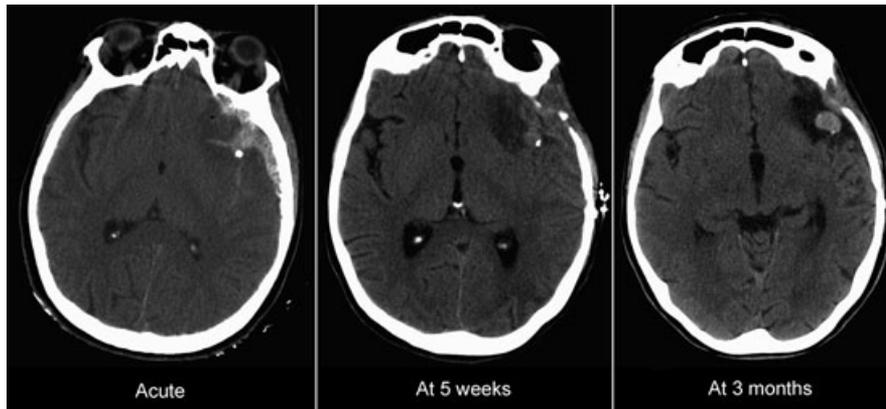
Initial head CT (acute) shows hemorrhagic contusions, subarachnoid hemorrhage, and a subdural hematoma on the left frontotemporal region, associated with pneumocephalus and presence of bone fragments in the temporal region, including the sylvian fissure. The last head CT performed prior to discharge (at 5 weeks) shows the aneurysm already present on the left temporal lobe, adjacent to the sylvian fissure. Head CT performed 3 months after discharge (at 3 months) shows that the aneurysm is increasing in size.
